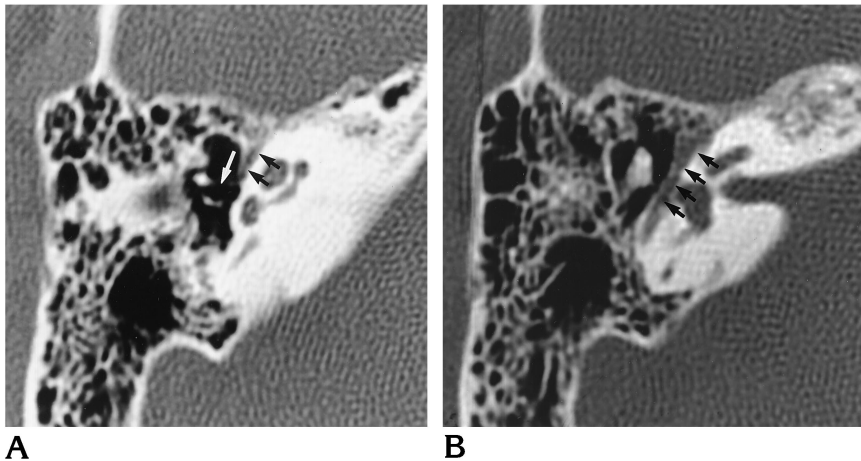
A, Tensor tympani muscle and tendon: axial CT scan shows the tensor tympani muscle (*black arrows*) within its canal. This muscle together with its tendon (*white arrow*) demarcates the floor of the anterior epitympanic recess.
